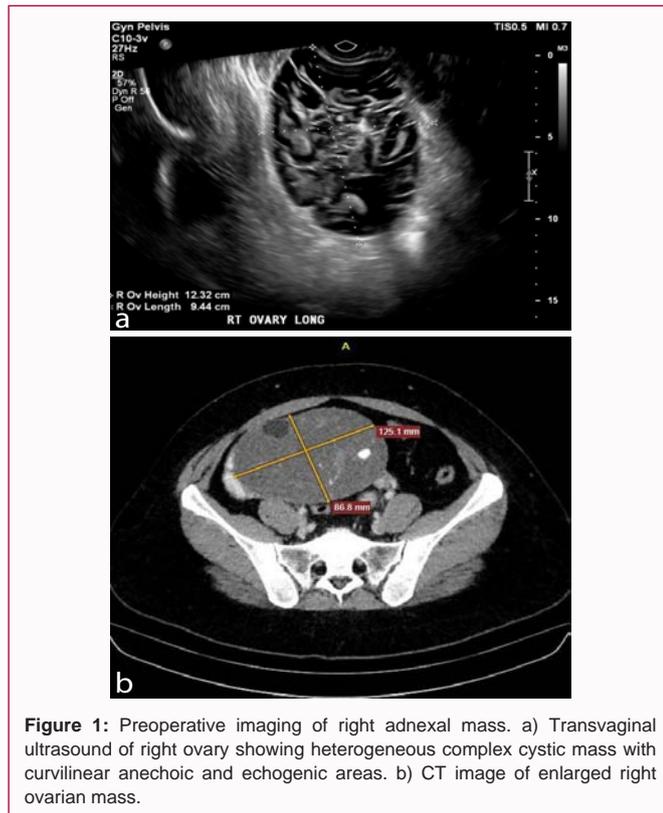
Preoperative imaging of right adnexal mass. a) Transvaginal ultrasound of right ovary showing heterogeneous complex cystic mass with curvilinear anechoic and echogenic areas. b) CT image of enlarged right ovarian mass.
